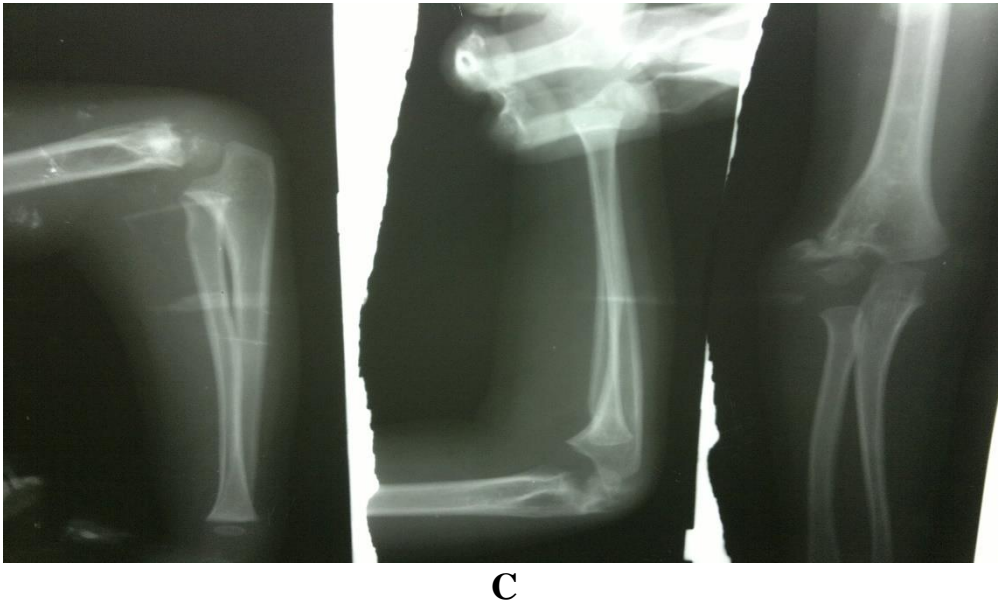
LCF presented after 42 days (A), Postoperative X-rays (B), Final follow up after 18 months show non-union (C).
